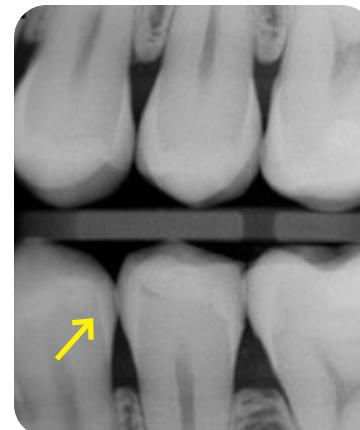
Opening all contacts often requires multiple bitewing orientations. Interproximal caries on teeth 20-21 are hidden by overlap in radiograph on left, but obvious in radiograph on right.
